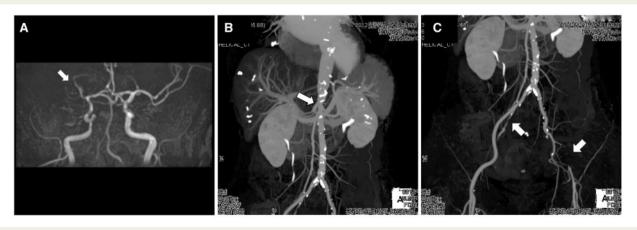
Magnetic resonance angiography shows stenosis of the right middle cerebral artery (A). Multiplanar reconstructed computed tomography angiography images indicate stenosis in the abdominal aorta at the proximal renal artery bifurcation (B) in addition to bilateral common iliac artery stenoses (C).
